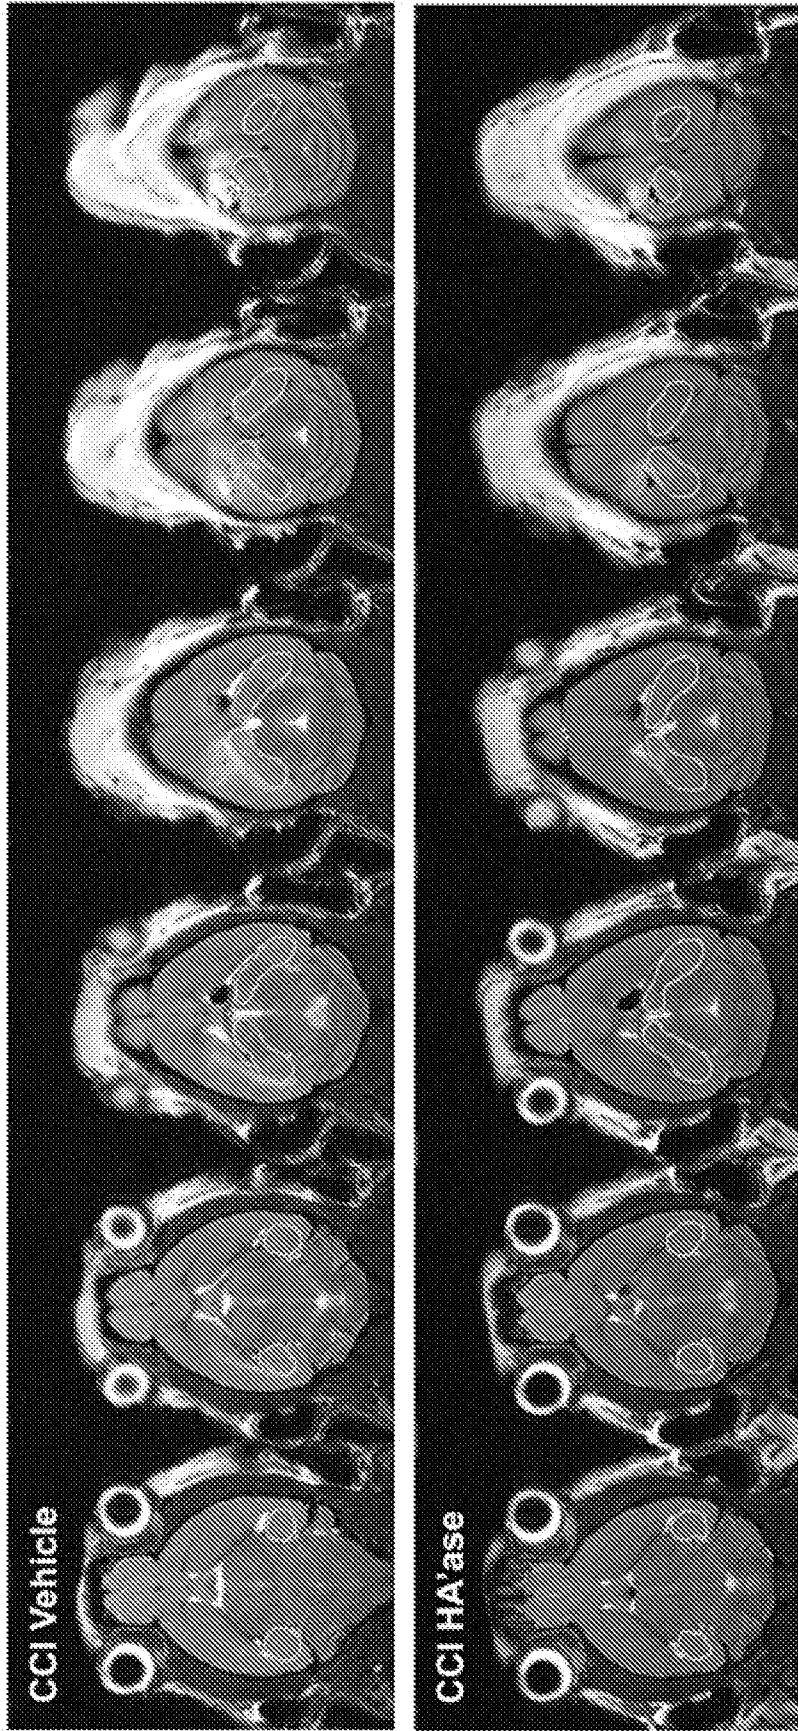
Edema in ipsilateral hippocampus (T2-weighted MRI)
